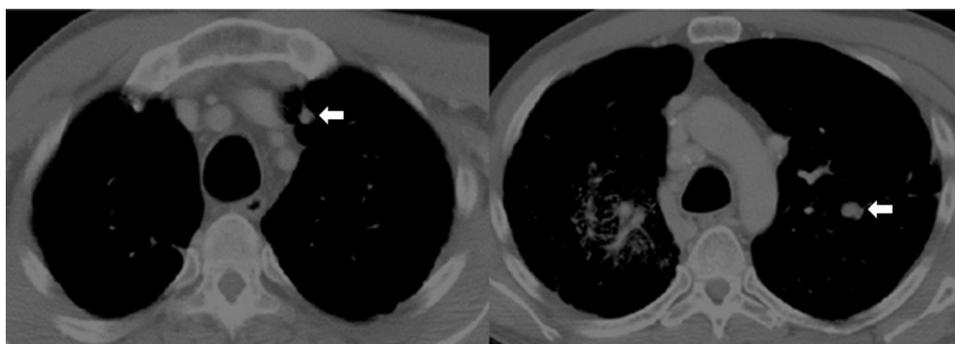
Thoracic CT (mediastinal window): 2 new pulmonary nodules (small arrows) in the left upper lobe with maximum diameters of 1 cm (right) and 1.1 cm (left).
